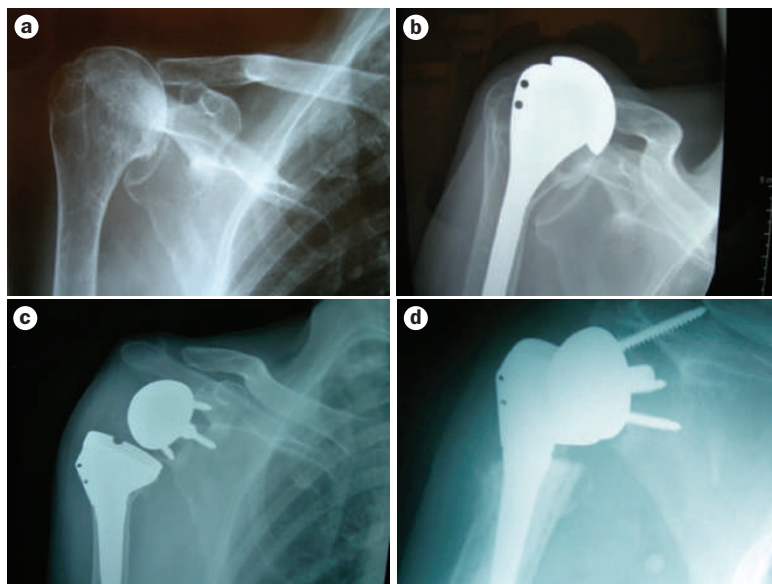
Management of a patient with a massive rotator cuff tear. a | Radiograph showing anterosuperior migration of the humeral head and arthritic changes of the glenohumeral joint. b | Radiograph showing treatment with hemiarthroplasty, with persistent anterosuperior migration. c | Radiograph showing implant revision to reverse total shoulder arthroplasty. d | Radiograph showing failure of the reverse total shoulder arthroplasty with dislocation.
